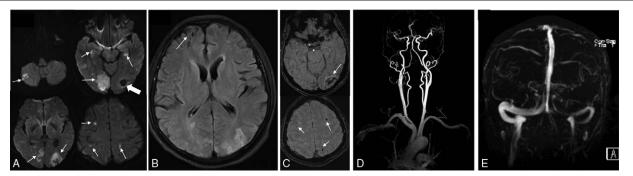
(A) MRI diffusion-weighted imaging sequence shows hyperintensity in the right cerebellum, bilateral hippocampus, occipital lobes, frontal and parietal lobes (thin arrow), a mixed signal in the left-occipital lobe (coarse arrow). (B) MRI T2/fluid-attenuated inversion recovery shows hypointensity in the right-frontal lobe (arrow). (C) MRI susceptibility-weighted imaging sequence shows hypointensity in the left-occipital lobe, bilateral frontal, and parietal lobes (arrow). (D) Magnetic resonance angiography (MRA) shows normal arteries. (E) Magnetic resonance venography (MRV) shows normal veins. MRA = magnetic resonance angiography, MRI = magnetic resonance venography.
